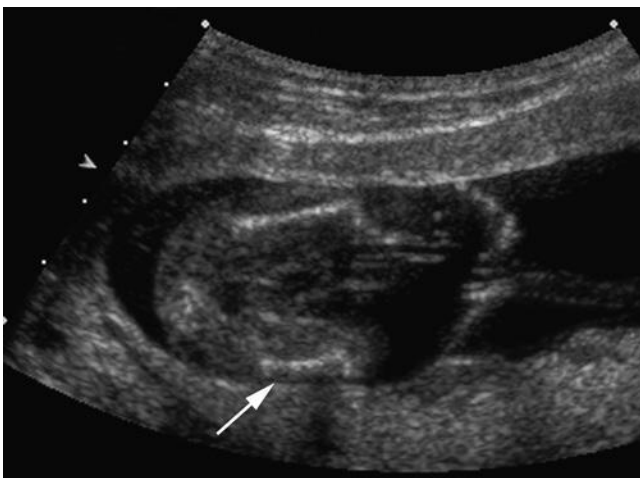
Second trimester sonogram in a fetus with proximal femoral focal deficiency. The right femur (arrow) is significantly shorter than the left femur.
